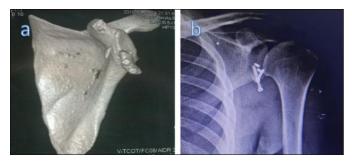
(a) 3D CT showing too low and lateral coracoid graft; (b) A/P x-ray showing more inferior graft and mal-directed screws
